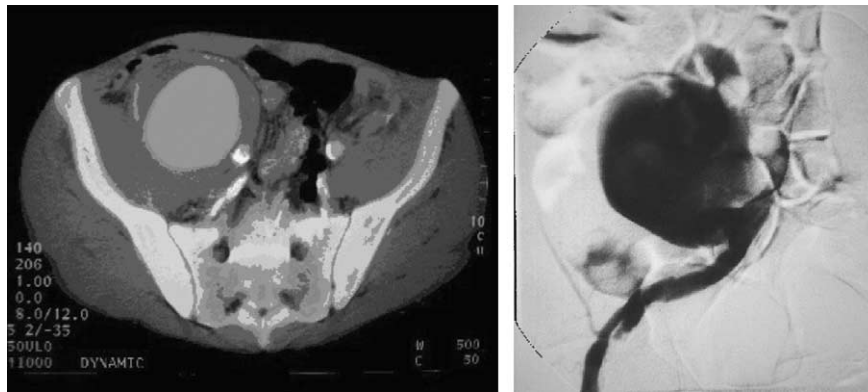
CT and angiographic appearance of external iliac pseudoaneurysm post-transplant nephrectomy.
